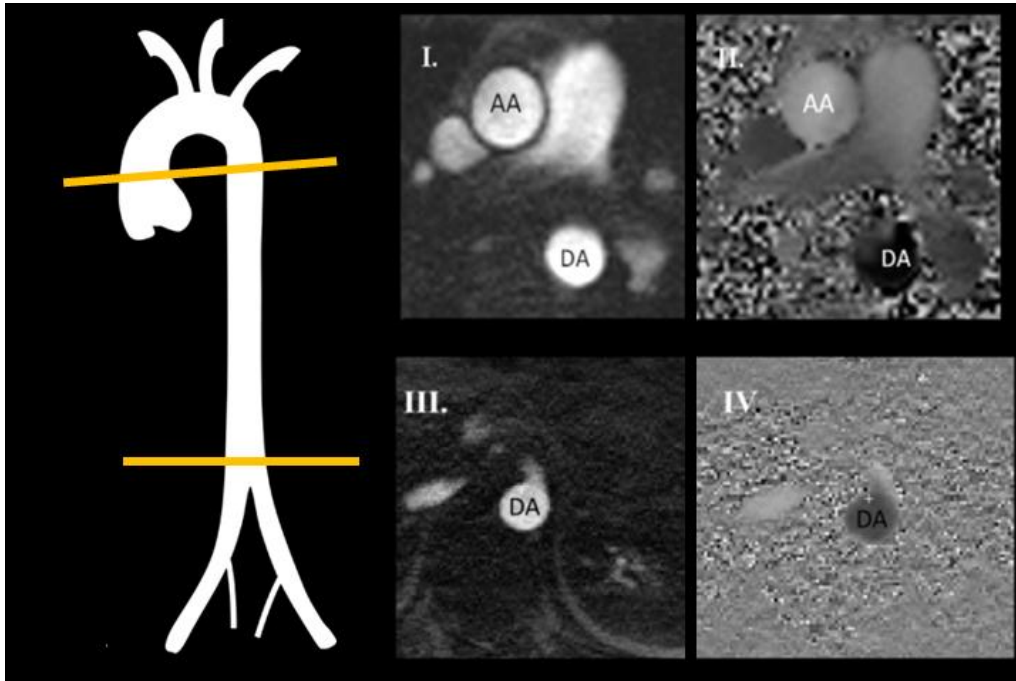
Through-plane cine PC-MRI mapping: (i) magnitude and (ii) phase at the aortic arch, and (iii) magnitude and (iv) phase above the renal bifurcation. Abbreviations: AA: ascending aorta, DA: descending aorta.
